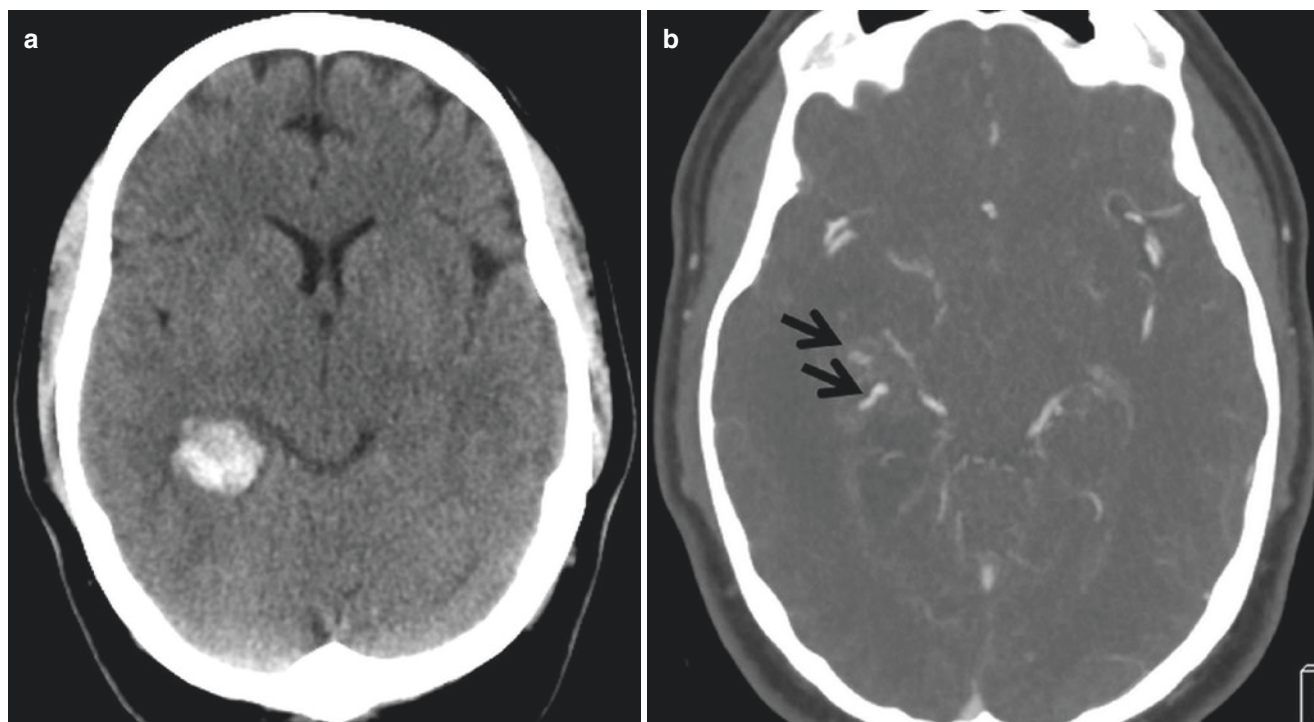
GBM mimicking AVM. (a) Patient presents with acute right temporal intraparenchymal hemorrhage. (b) Axial CTA shows a cluster of abnormal vessels adjacent to the hemorrhage (arrow) suspicious for a small AVM, although catheter angiogram does not confirm the presumed diagnosis. (c) Three-month follow-up NCCT demonstrates a
